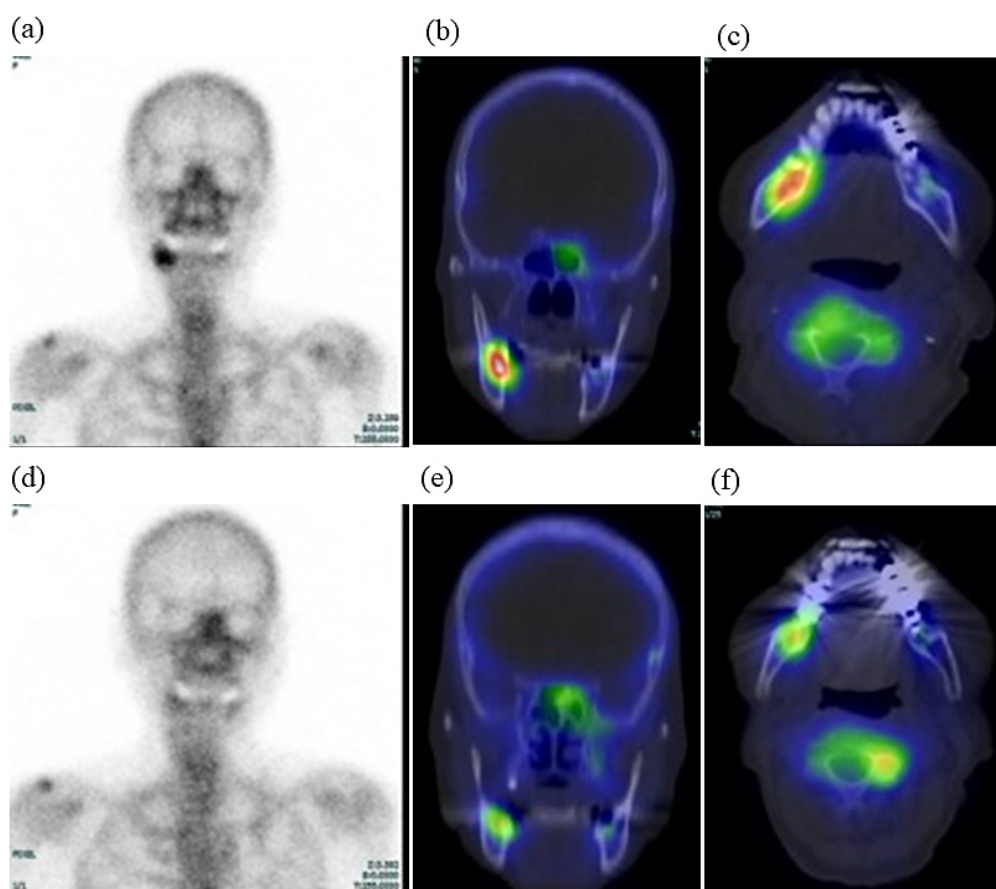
Pre- and post-treatment bone SPECT/CT findings in 88-year-old female with stage 2 MRONJ. (a–c) Pre-treatment and (d–f) post-treatment SPECT/CT images of the right mandible are shown (a, d: planar; b, e: coronal bone SPECT/CT; c, f: axial bone SPECT/CT). Before treatment, SUVmax, SUVpeak, SUVmean, MBV, and TBU values were 7.83, 6.44, 4.58, 8.23 mL, and 37.71, respectively. Following antimicrobial therapy, those were decreased to 2.98, 2.56, 1.79, 5.16 mL, and 9.23, respectively, consistent with treatment response.
